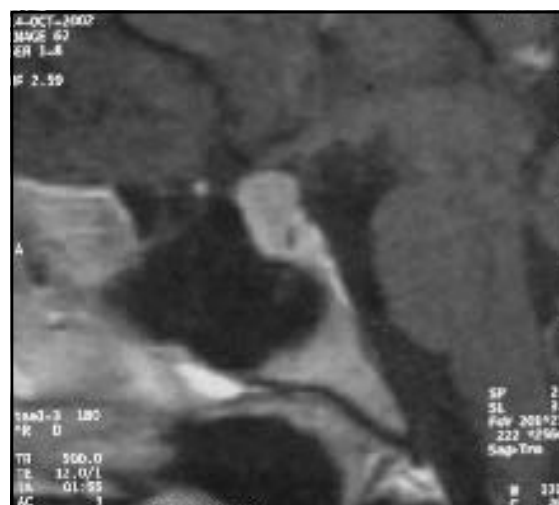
Micro adenoma in MRI of pituitary of the patient in sagittal view.
